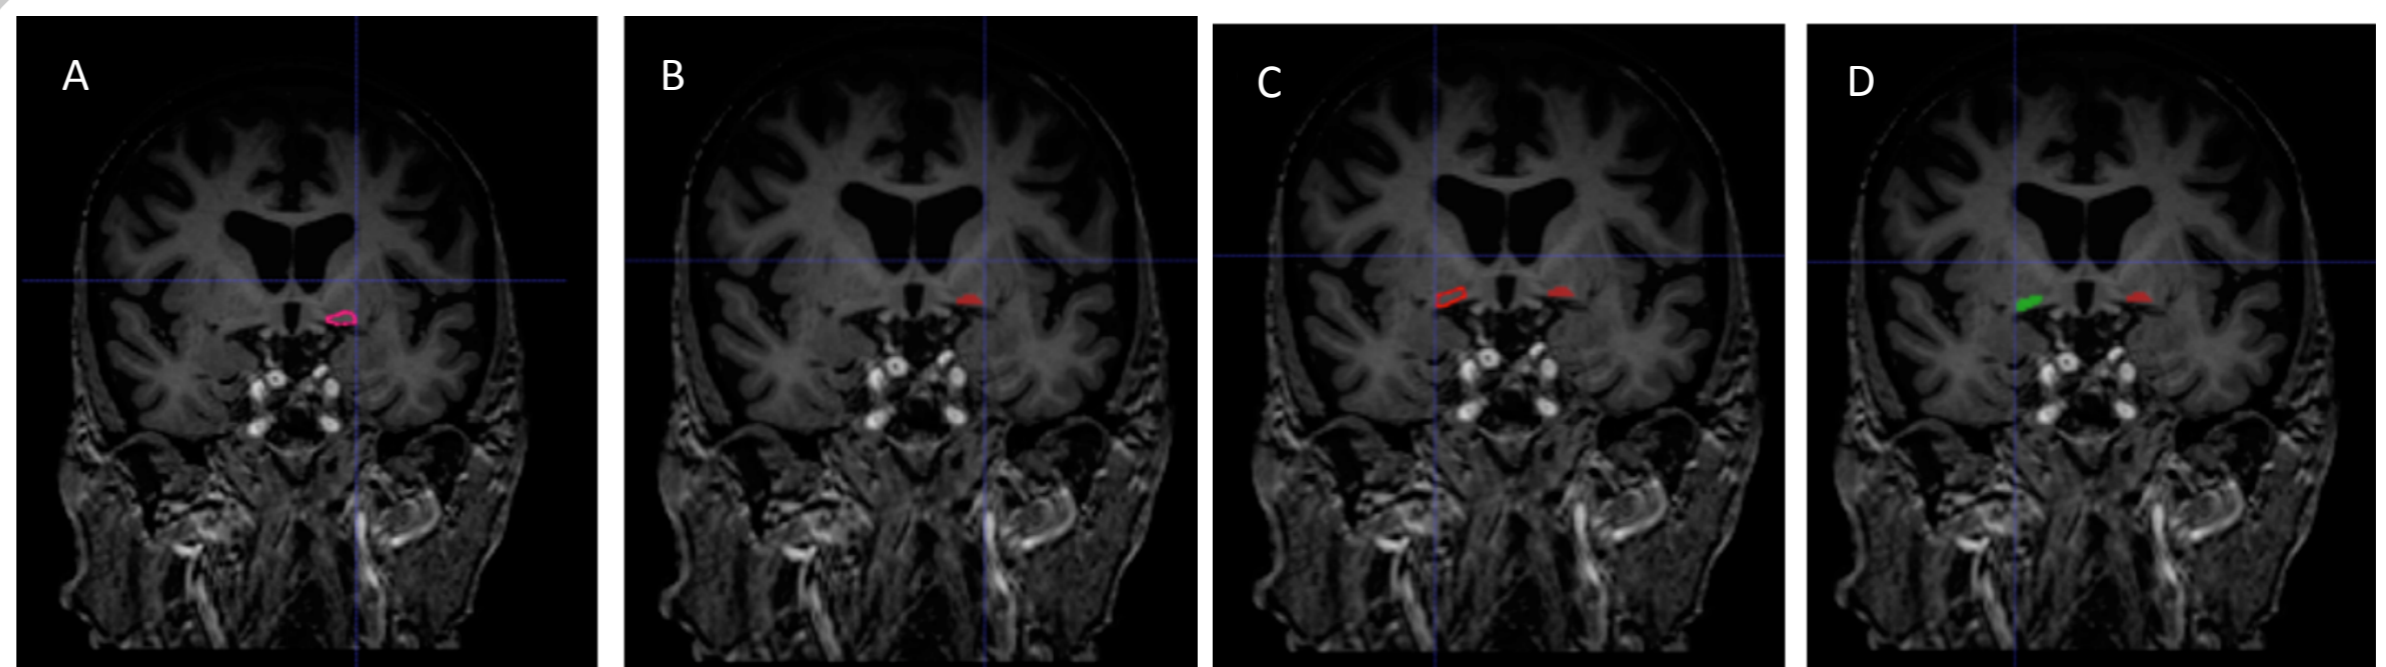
MRI scans showing a segmented SI
